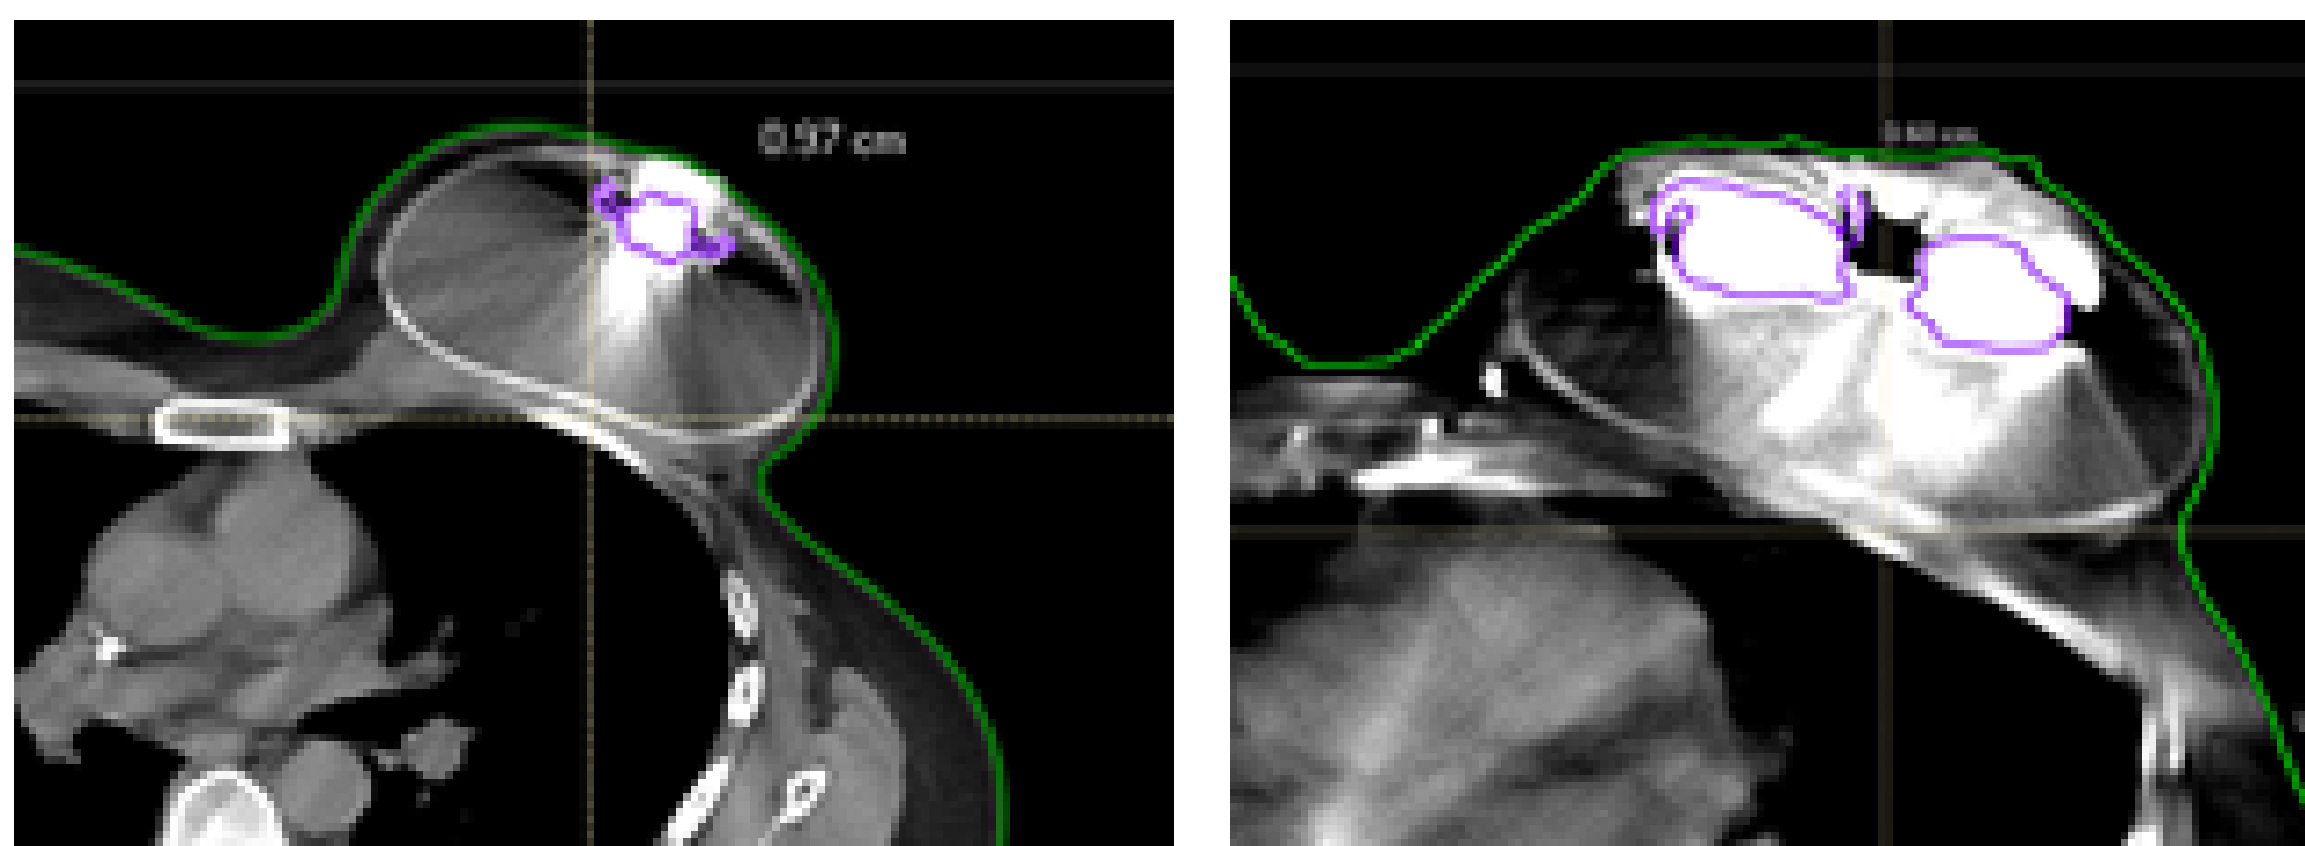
CT scan of breast patients with metallic breast expanders.
